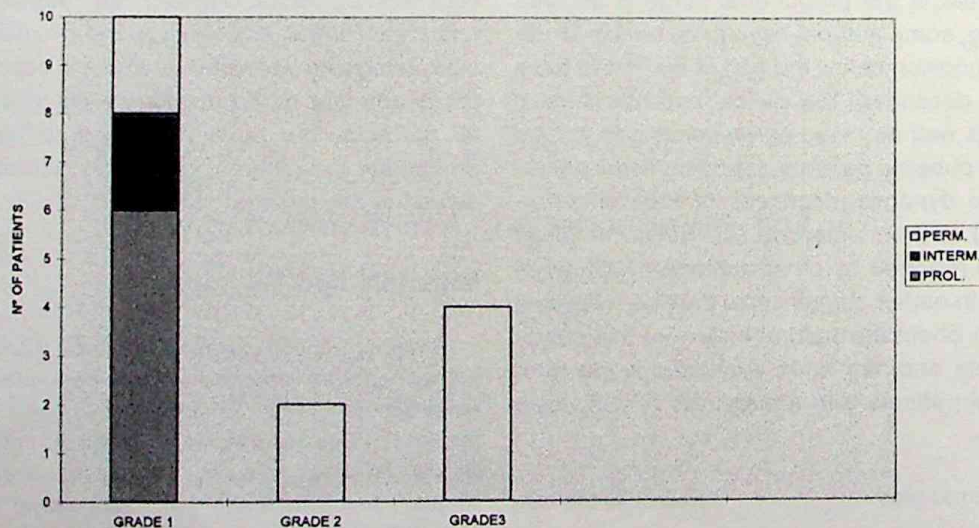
Correlation between clinical and Doppler findings
